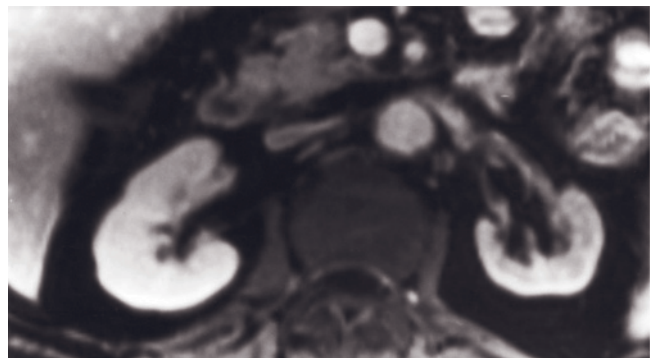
Ischemic nephropathy. T1-weighted immediate (a) and 2-min (b) postgadolinium SGE images in 2 patients. In these patients atherosclerotic disease of the aorta is present, and the involved left kidney is small and smooth and has uniform cortical thinning. The diseased kidney enhances in a diminished fashion compared to the normal right kidney on immediate postgadolinium image (a). Corticomedullary differentiation develops later and persists in a more prolonged fashion on late-phase image (b). The renal collecting systems are normal in caliber, which is an important observation to exclude obstructive nephropathy.
